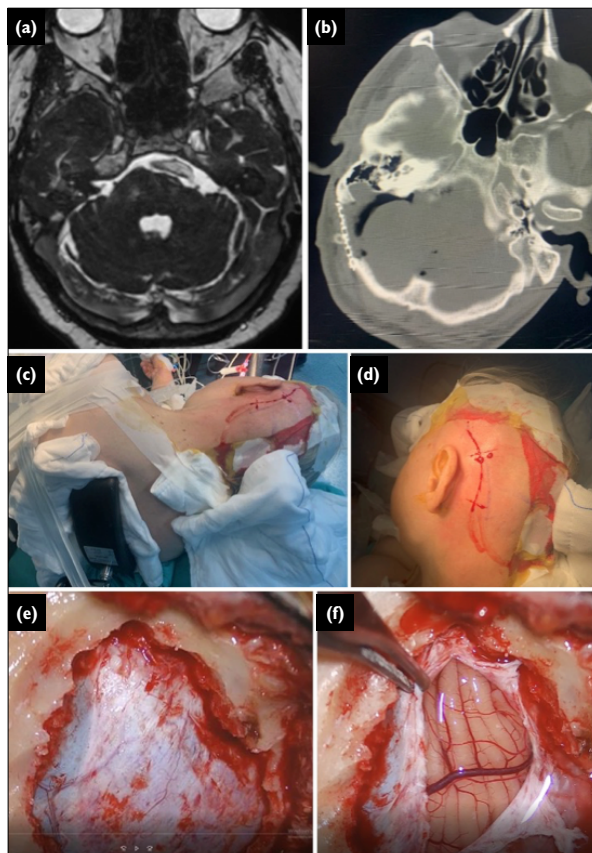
(a) Preoperative magnetic resonance imaging, and (b) postoperative computed tomography of the patient. (c) Surgical positioning in lateral decubitus, (d) Right retroauricular skin incision. (e) After retrosigmoid craniectomy, (f) After limited dural opening.
